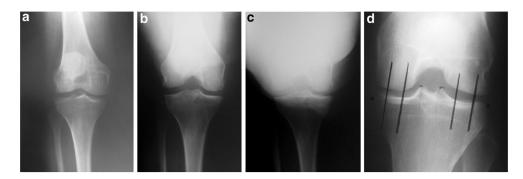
Standing weight-bearing knee radiography of a patient in 0, 30 and 45° of flexion (a, b, c). The radiographic measurement of joint width in six compartments (d)
